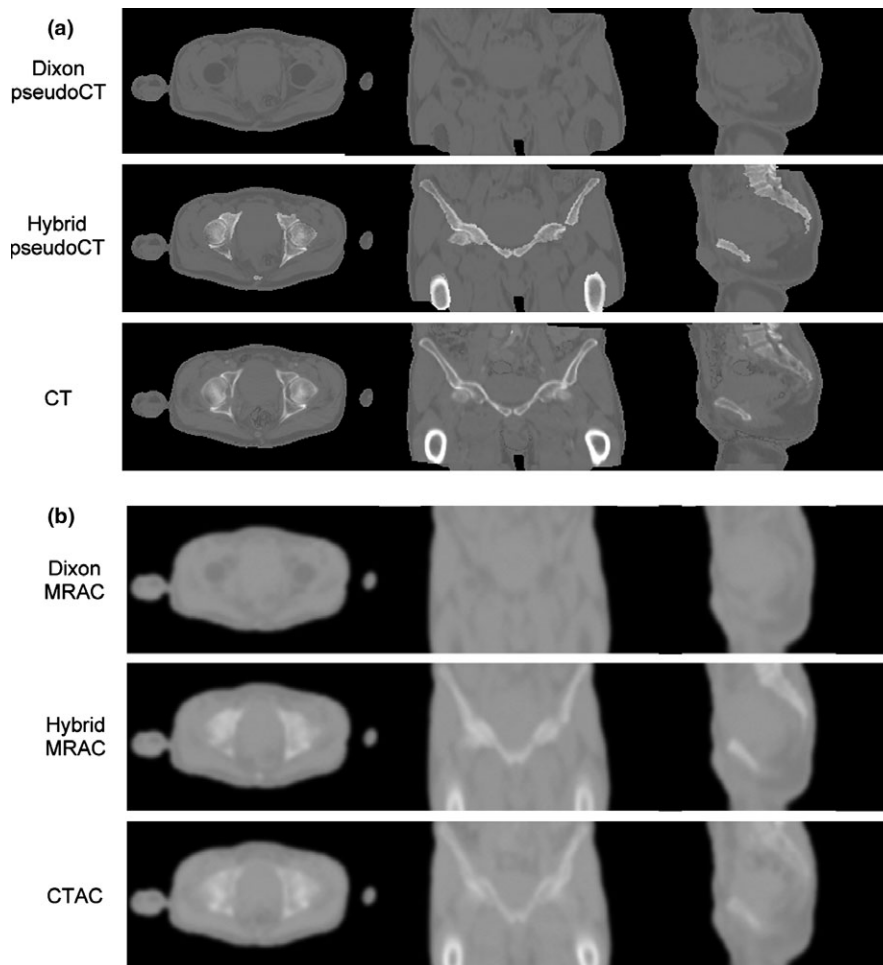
Dixon pseudoCT (a, top row) and MRAC (b, top row) and hybrid ZTE/Dixon pseudoCT (a, middle row) and MRAC (b, middle row), vs CT (a, bottom row) and CTAC (c, bottom row) for patient #1. The ZTE-derived bone from Fig. 2 is added to the Dixon pseudoCT using the model proposed in Fig. 3. The bowel air and arms from the Dixon pseudoCT are copied to CT images to account for differences in air distribution and arm positioning.
